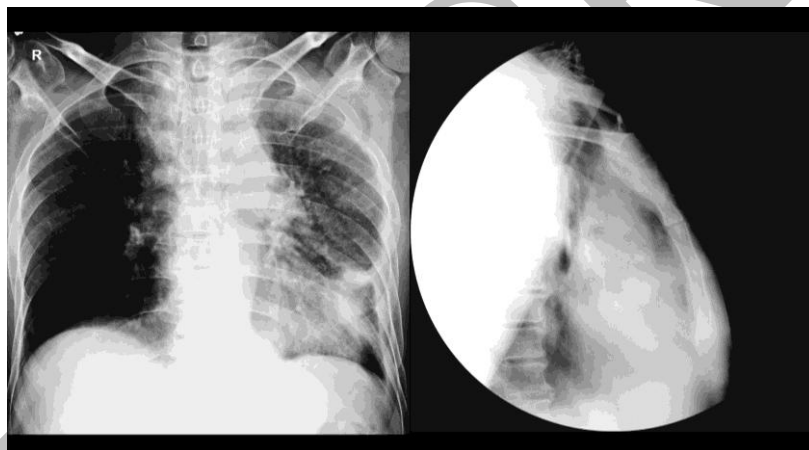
Chest radiograph AP and Lateral views showing widened superior mediastinum, small left pleural effusion and sternal erosion with soft tissue mass.
